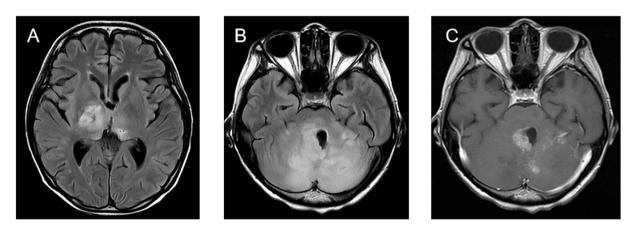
Head magnetic resonance imaging (February 2024). Images captured at (A) the level of the bilateral thalamic brain structure, (B) at the level of the dorsal pontine brain structure and (C) at the level of the cerebellar bulbs brain structure. Multiple areas of oedema are seen, indicating that the tumour is progressing.
